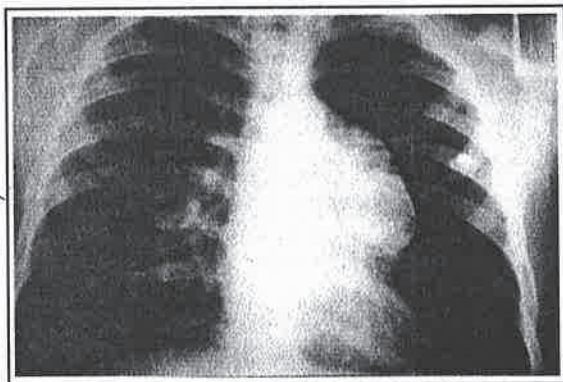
PA X-Ray Image of a case with "Hodgkin Lymphoma"
